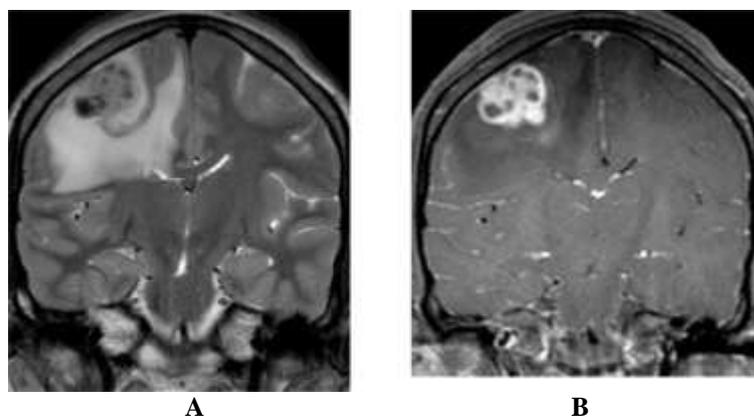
Intracranial tuberculomas in 17 year old female. MRI showing multiple conglomerate T2 hypointense lesions in the right frontoparietal region with perilesional edema and ring enhancement on post contrast study suggestive of tuberculomas.
